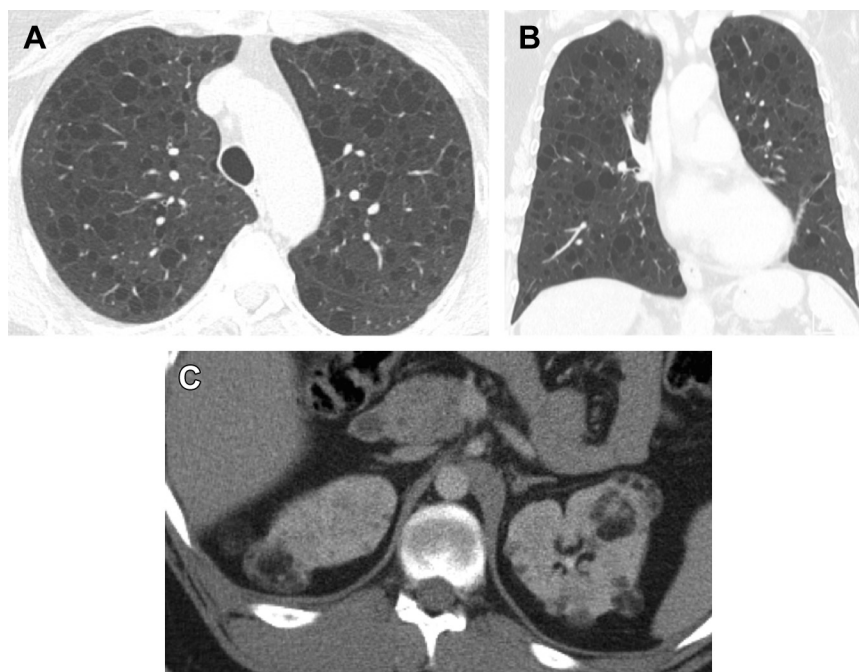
Lymphangioleiomyomatosis. (A) Axial CT shows round, uniform cysts with normal intervening lung parenchyma. (B) Coronal reformation showing diffuse distribution of cysts without zonal predominance. (C) Axial CT of the abdomen showing multiple fat-attenuation lesions in both kidneys, consistent with angiomyolipomas in a patient with tuberous sclerosis. Grossly, one can infer that the lesions are fatty by comparing the internal density with that of adjacent abdominal fat.
